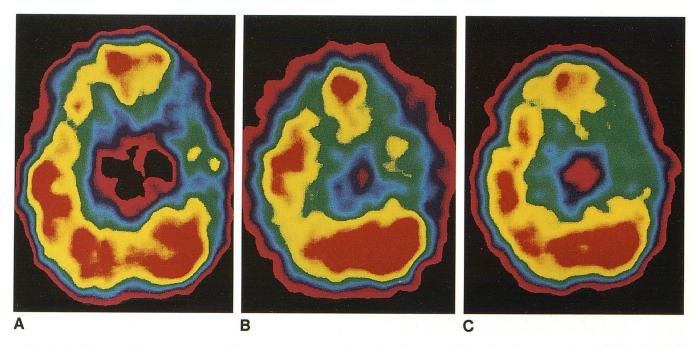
A, 31-year-old woman with partial seizures originating from the left temporal lobe that shows a reduced rCBF in HMPAO SPECT.
